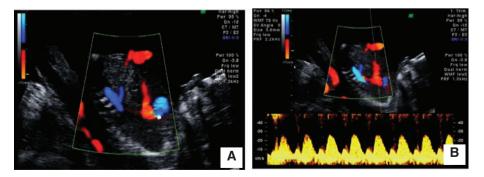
Ultrasonographic and Doppler blood flow evaluation in two cases of DV agenesis at 16 weeks of gestation.
